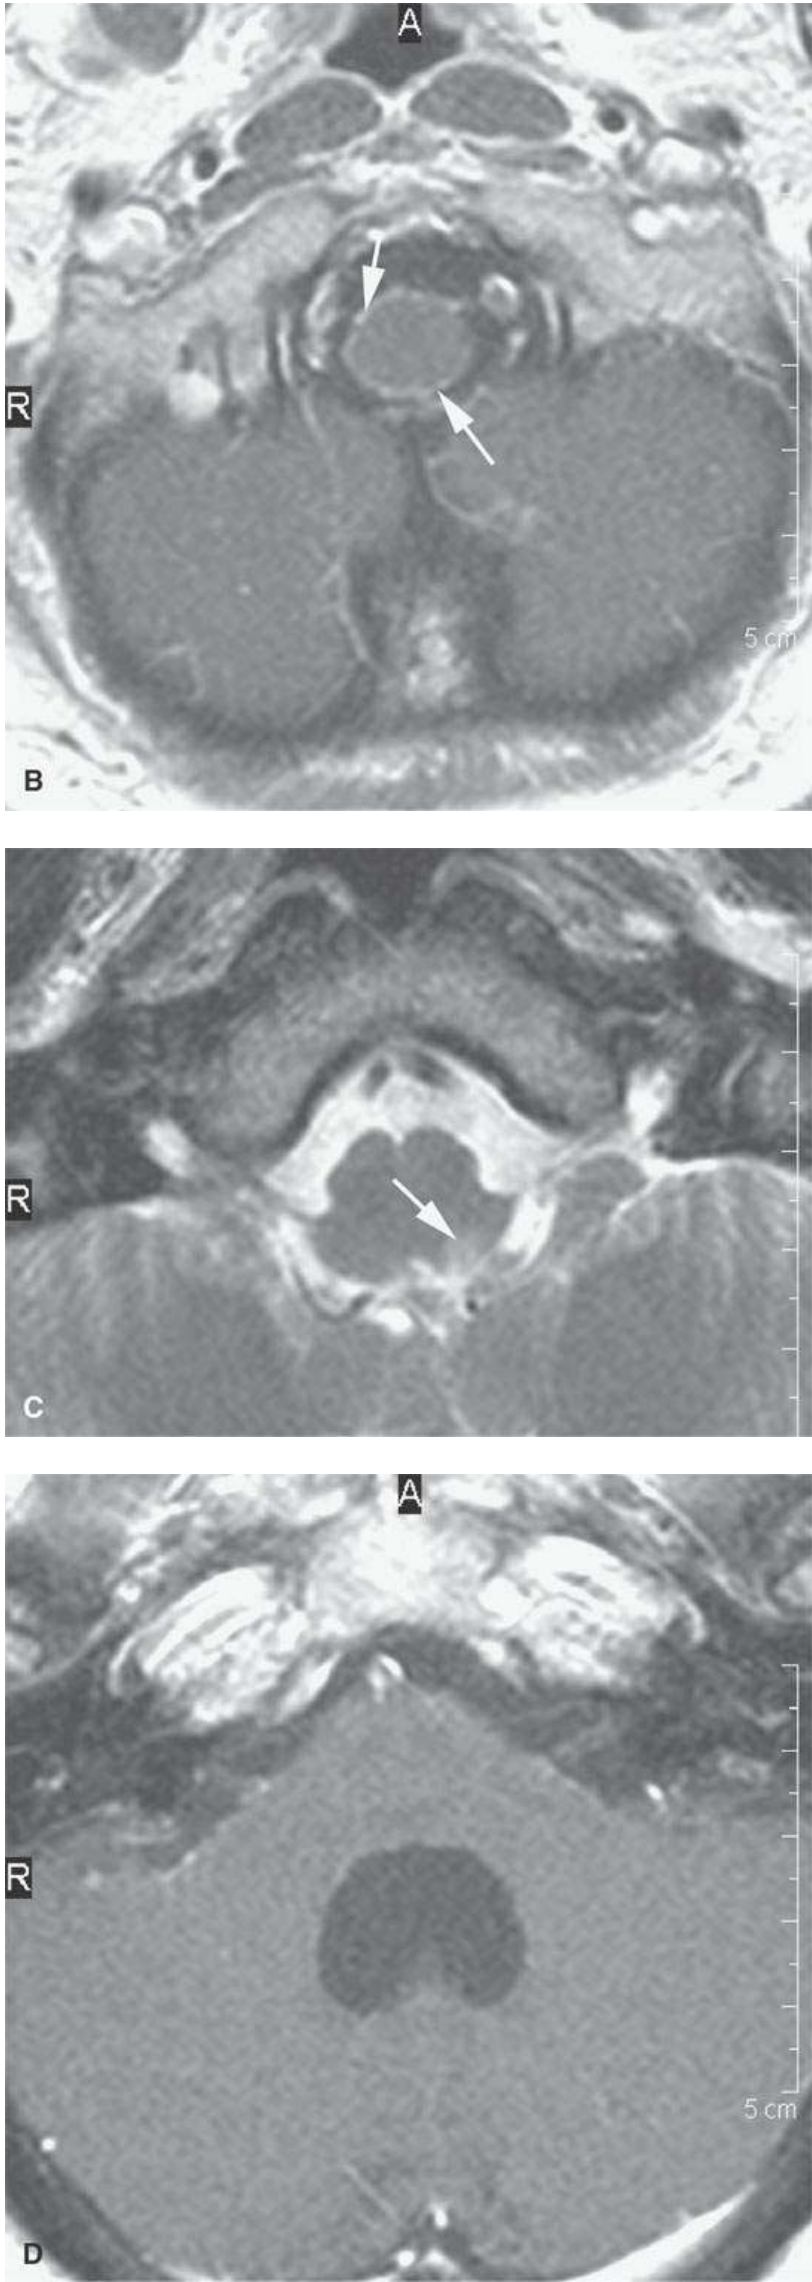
Meningeal carcinomatosis as seen on magnetic resonance imaging manifesting as nodular enhancement of the pia-arachnoid membrane (arrowsheads on the T1-weighted contrast-enhanced images in A and B) and edema along the surface of the brain stem (arrow in the T2-weighted image in C), and obstruction of the fourth ventricle (T1-weighted contrast-enhanced images in D).
